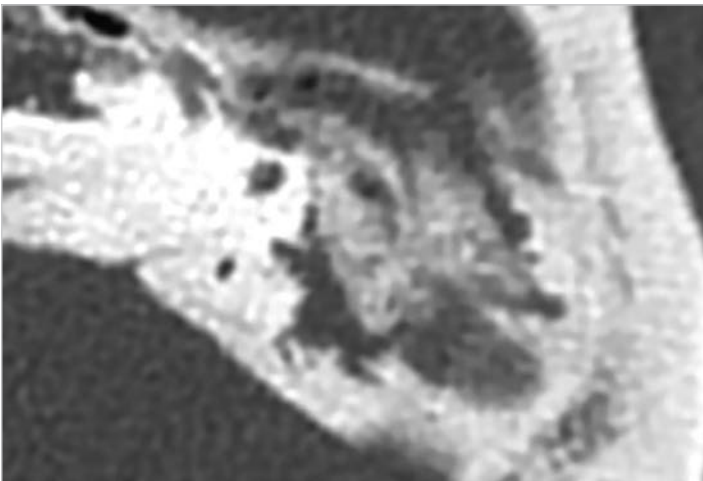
Axial CT image of cholesteatoma with new bone formation (*left ear*). A large newly formed bone is identified in the cholesteatoma. Cholesteatoma matrix is identified under the bone during surgery. Failure of complete removal of this bone will cause relapse of the disease.
